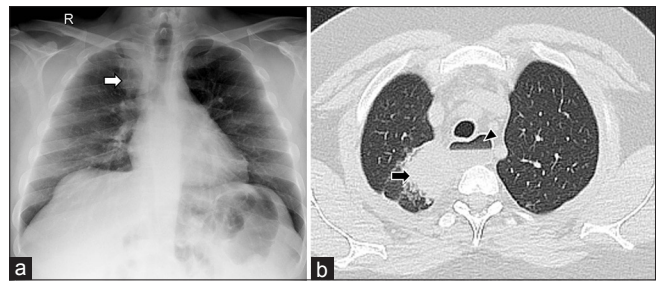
(a) Initial chest X-ray showed right apical lung opacity (arrow). (b) Same-date high-resolution chest computed tomography showing that the lesion is mass like and is located in the apical segment of the right upper lobe (arrow). The computed tomography also showed a dilated esophagus with a luminal fluid level (arrowhead)
